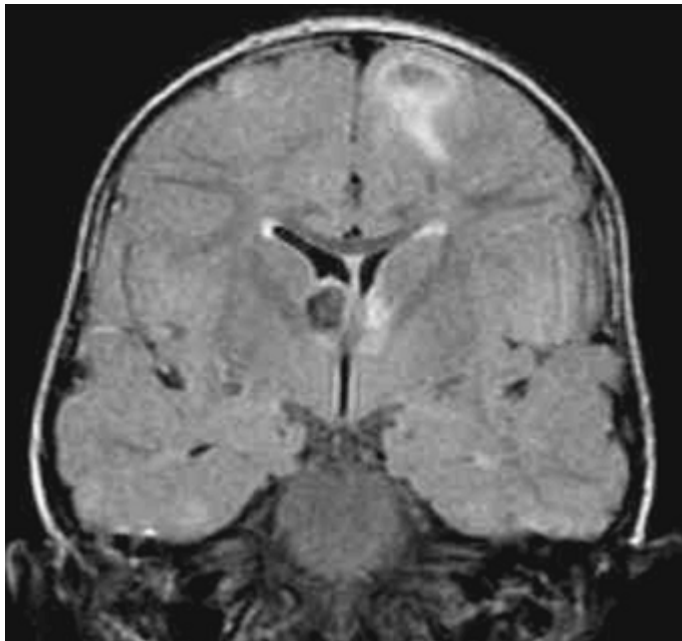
Tuberous sclerosis complex. Coronal fluid-attenuated inversion recovery magnetic resonance image shows multiple hamartomas and a large subependymal nodule.
